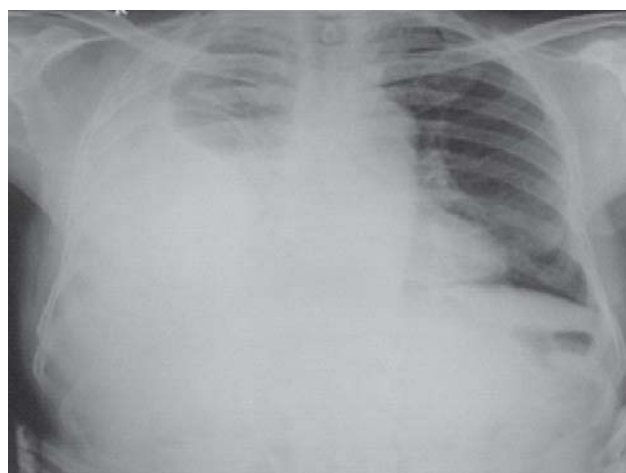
Chest radiograph (postero-anterior view) after right percutaneous nephrolithotomy and cystolithotripsy showing right-sided pleural effusion.
